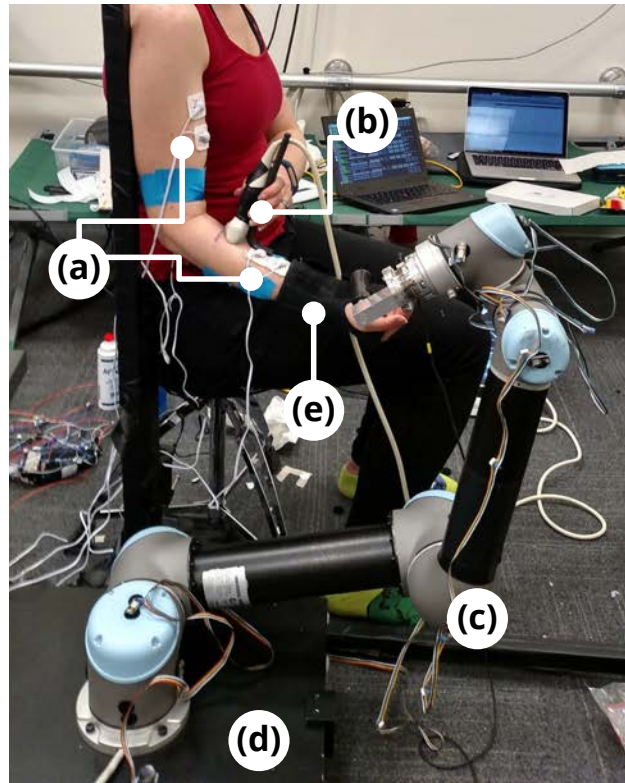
Experimental setup for the collection of time series force, surface electromyography (sEMG), and ultrasound data under multiple elbow angles. Setup includes sEMG electrodes (a); ultrasound probe (b); UR5 robot (c) with attached handle, through which subject may transmit force to force plate (d); and wrist brace (e) for elbow isolation. ©2020 IEEE.
